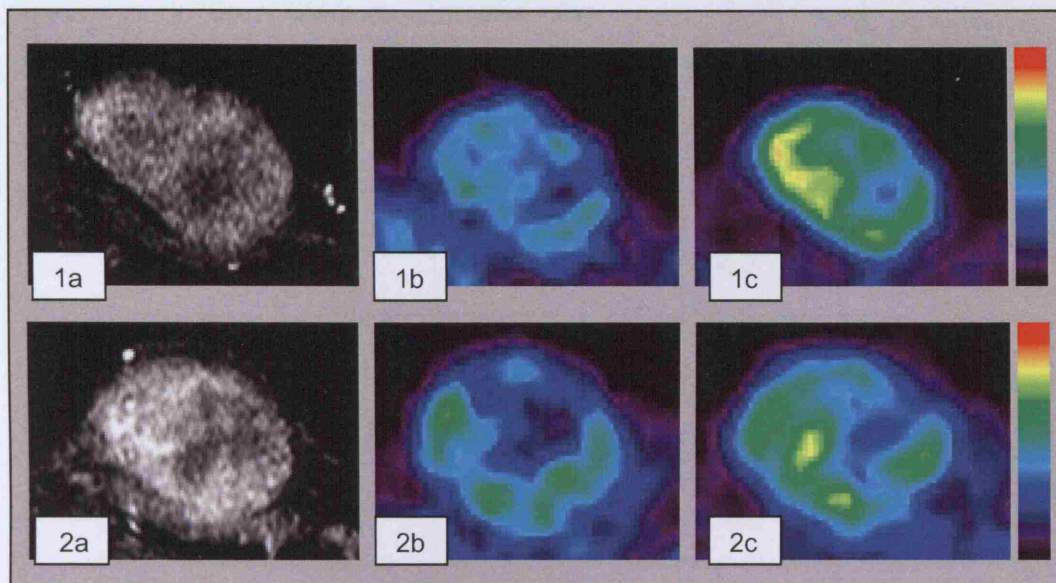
Corresponding Gadolinium-enhanced MRI and microPET images. Images sets 1 and 2 represent two different control tumours. Image 1a and 2a are Gadolinium-enhanced images 90 seconds from the beginning of the Gadolinium infusion. The bright regions represent Gadolinium uptake, therefore blood flow. Images 1b and 2b are 0-10 minute microPET acquisitions and images 1c and 2c are 50-60 minute acquisitions. The ^{64}Cu -ATSM uptake in the 0-10 minute images was significantly similar to the Gadolinium uptake. Although the uptake of ^{64}Cu -ATSM in the 50-60 minute PET images was not significantly correlated the distribution looks similar to the distribution of Gadolinium even at this late stage.
